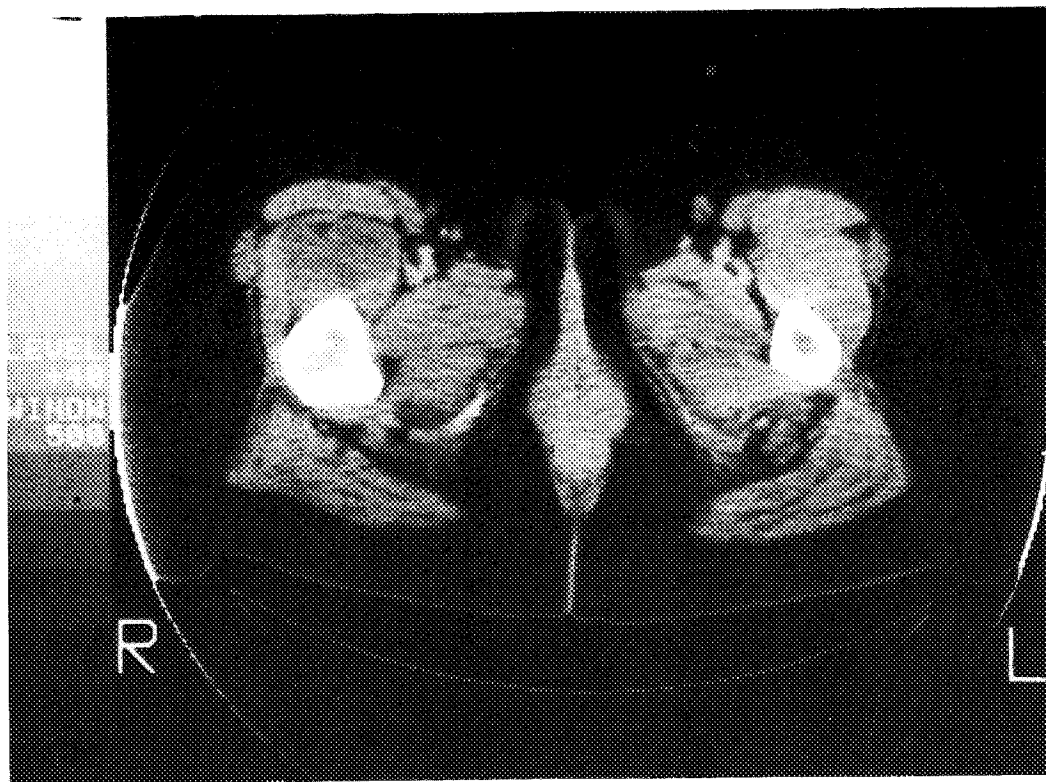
Computed tomography at thigh level. A rather large mass of soft-tissue density is demonstrated on this view in the right rectus femoris muscle region. Also of note is the large diameter of the femur itself on the right.
